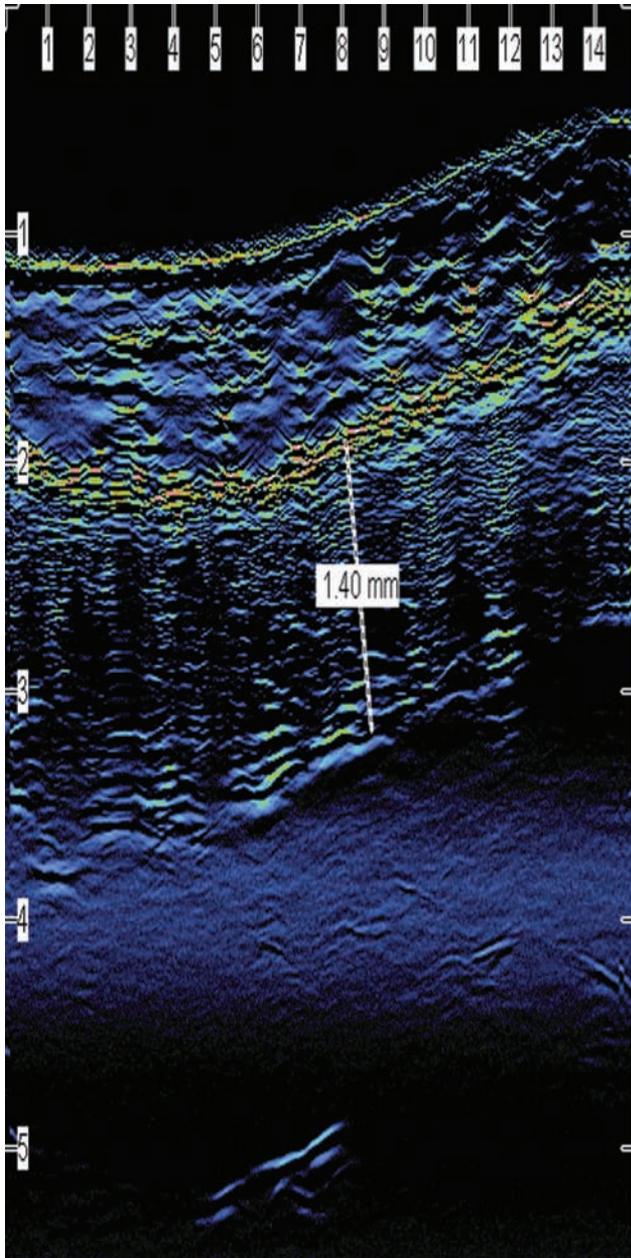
Ultrasound image of healthy skin.
